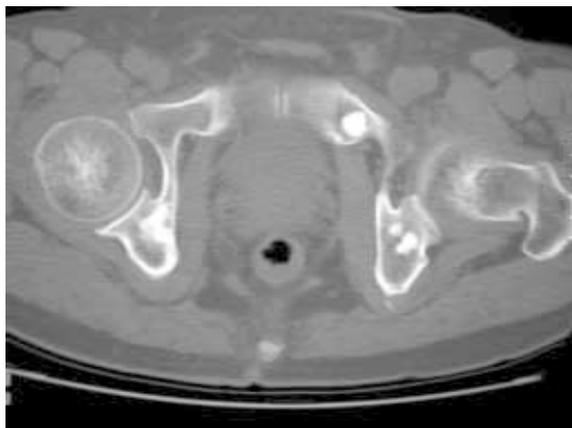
73-year-old man with prostatic carcinoma. Axial CT scan of the lower pelvis shows several sclerotic metastases.
